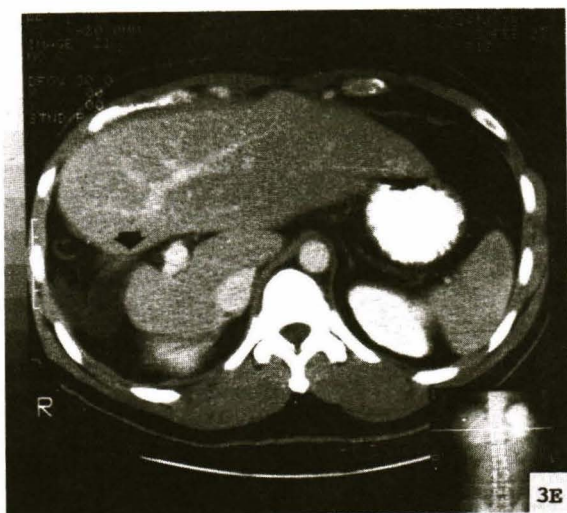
Follow-up contrast enhanced CT scan (same case as Fig. 3A) shows defect in right lobe from wedge hepatic resection (arrow). No residual tumor seen.
